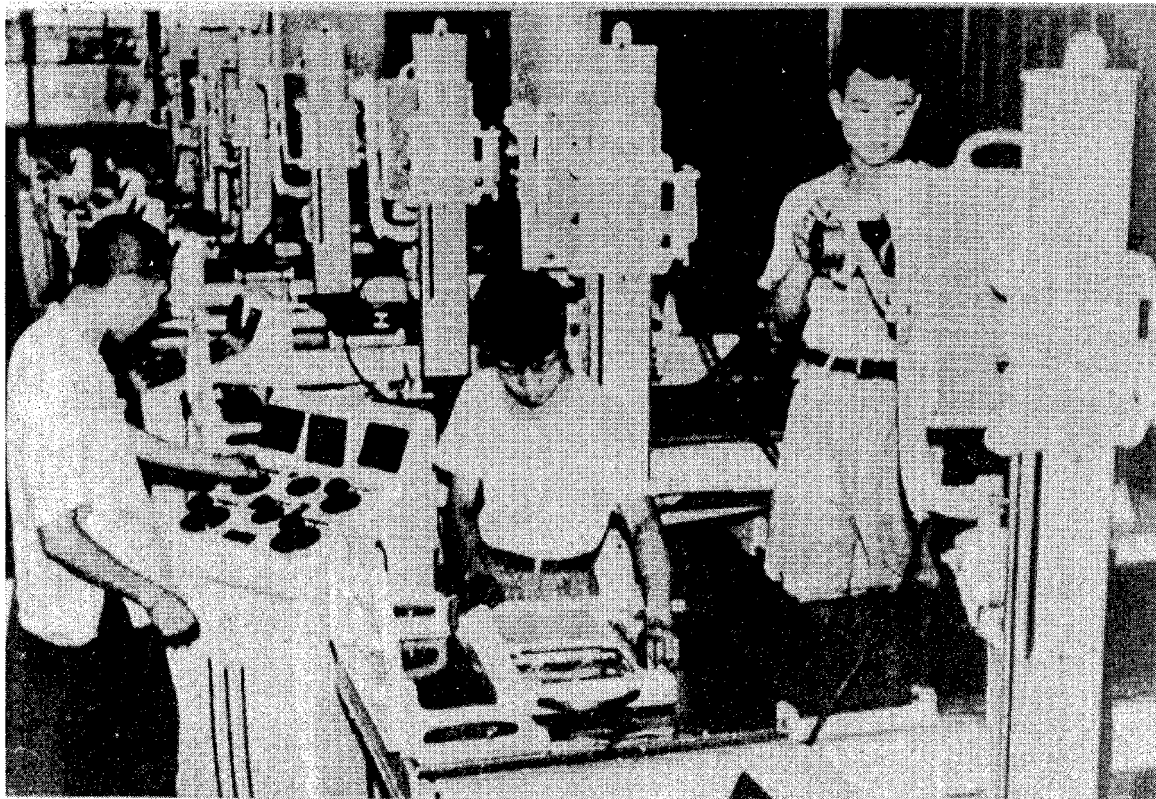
X-ray machines manufactured at the Shanghai Medical Precision Instruments Factory.
